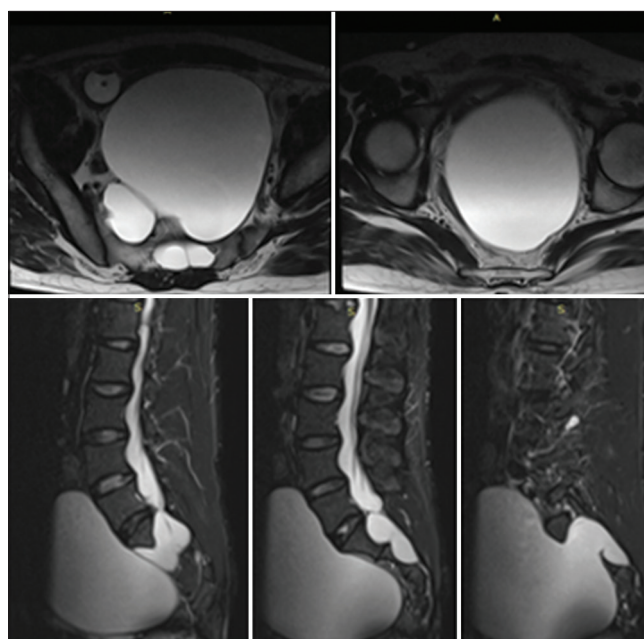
Preoperative axial and sagittal T2-W magnetic resonance imaging scan Lumbo-Sacral (LS) spine. The T2-hypointense lesion originates from bilateral neural foramen at the level of S2. Appreciate the septa between two sides of the cavities within the pelvis. Bony elements are seen missing at levels S2-4.
